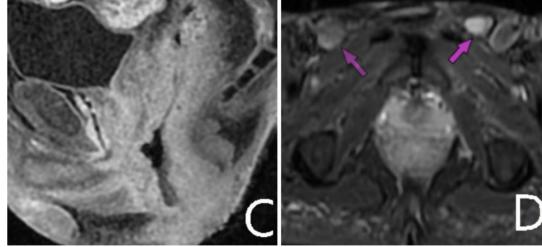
Img. A. T2-weighted sequences show diffuse and symmetrical parietal thickening, with abundant trabeculation of the mesorectum. B. Axial sections, showing the symmetry of the condition, as well as the spiculation of the fat
